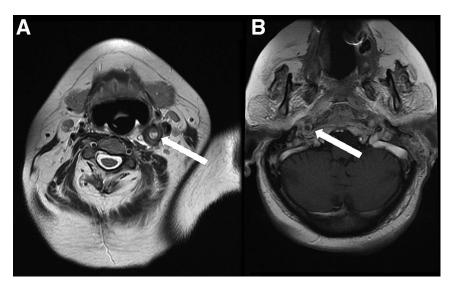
(A) Magnetic resonance (MR) image showing enlargement and abnormal T2 signal along the left internal carotid artery (ICA) suggestive of thrombus within the vessel. (B) MR image demonstrating narrowing and enhancement of the right ICA at the cervical/petrous junction.
